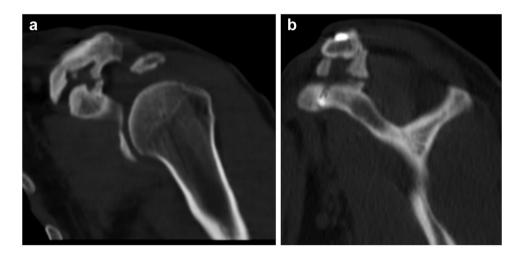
(a) Coronal and (b) sagittal computed tomography scan images of a patient showing apparent heterotopic ossification located around the tunnel.
